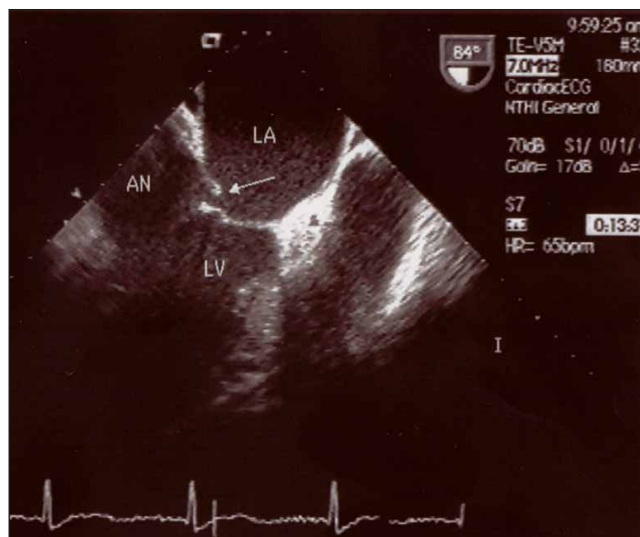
Transoesophageal echocardiography showing rupture of commissural chordae of the posterior mitral leaflet.
